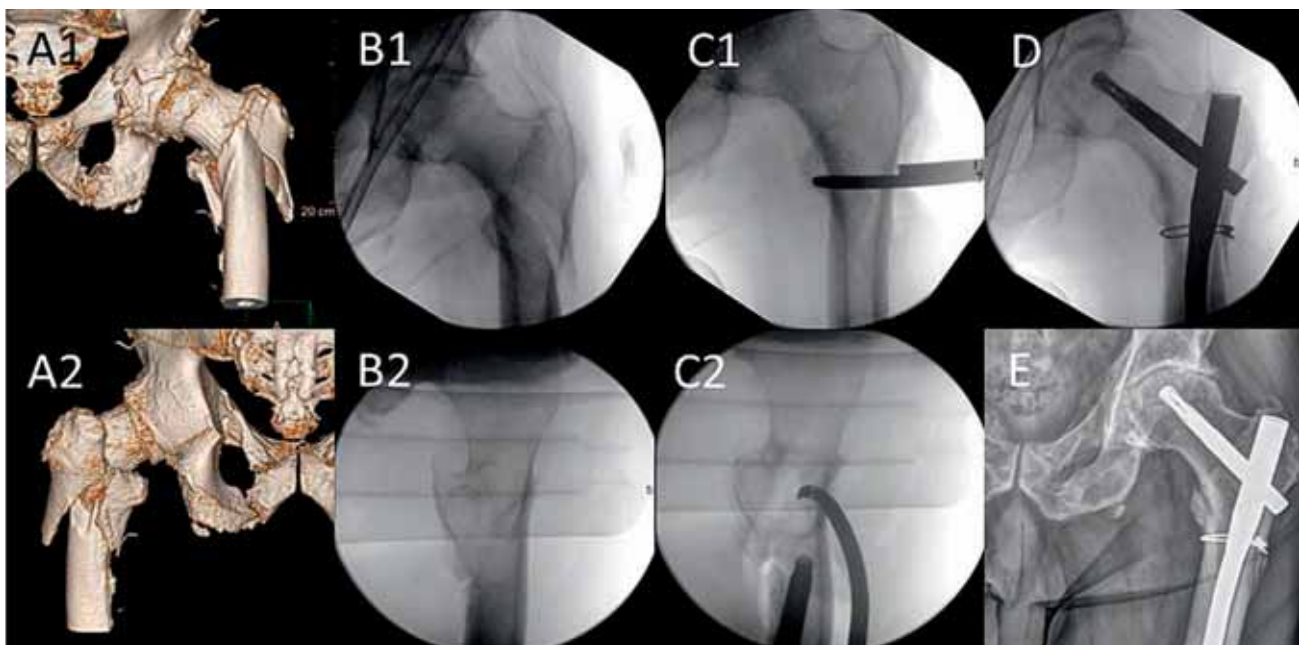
Case presentation of a 70-year-old male patient who sustained a multiple trauma including injuries to the chest with multiple rib fractures and a pneumothorax, a pelvic ring fracture (sacrum and anterior ring) with involvement of the left acetabulum (undisplaced fracture) and a displaced unstable fracture of the left proximal femur. A1 and A2 – 3D-CT reconstructions, views from anterior (A1) and posterior (A2). AO 31-A3 fracture. B1 and B2 – AP and lateral view. Careful closed reduction on the traction table in order to avoid displacement of the fractures of the pelvic ring and acetabulum. C1 and C2 – AP and lateral view. A limited open approach was performed and a collinear reduction clamp applied to reduce the remaining varus deformity. No instruments were used proximal to the lesser trochanter to avoid damage to the blood supply of the femoral head. D – AP view. The long PFNA was introduced and the collinear reduction clamp replaced with a cable to augment stability of the osteosynthesis. E – AP view. Follow-up after 3 months of partial weight bearing showed progressive osseous consolidation of the fracture without secondary displacement.
